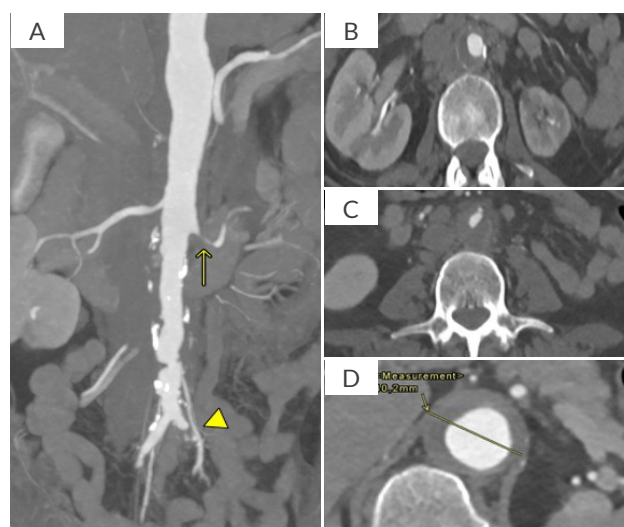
Computed tomography angiography of the A-D) abdominal aorta demonstrates severe eccentric noncalcified “soft” and mildly calcified atheromatous plaque; B,C) The lumen of the infrarenal aorta is unevenly narrowed. We can also appreciate D) mild dilatation of descending thoracoabdominal aorta, severe stenosis of the left renal artery with atrophy of the left kidney (arrow ←) and chronic occlusion of left common iliac artery (arrow ◄).
